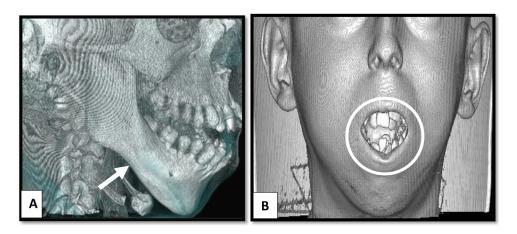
(A) 3D CT scan reconstruction in profile view revealing antegonial bone depression (white arrow). (B) 3D CT scan reconstruction in frontal view revealing dental crowding and labial incompetence (circle).
